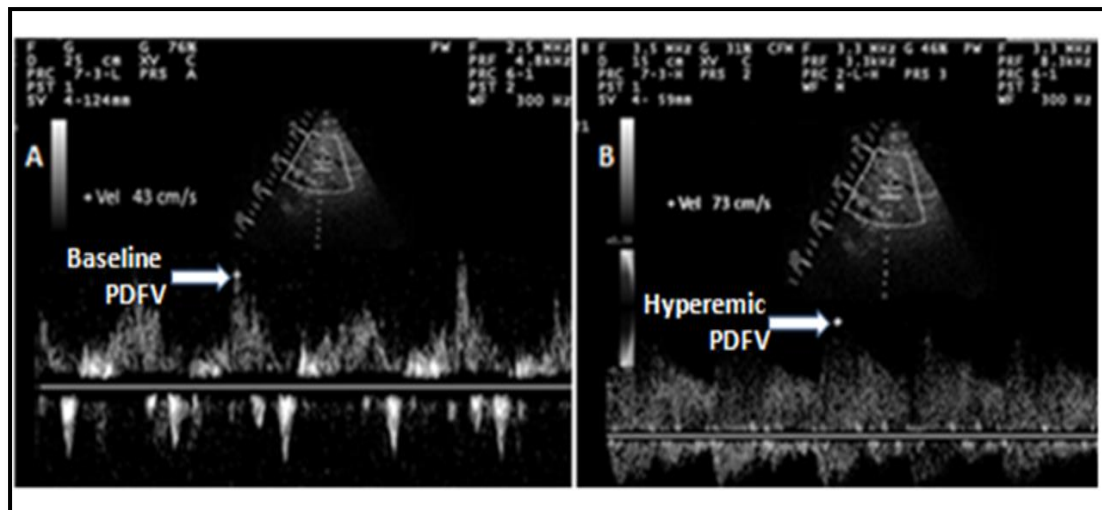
Spectral Doppler image with transthoracic echocardiography of coronary flow. A- Baseline peak Diastolic Coronary Flow Velocity (Baseline PDFV). B-Hyperemic peak Diastolic Coronary Flow Velocity (Hyperemic PDFV).
